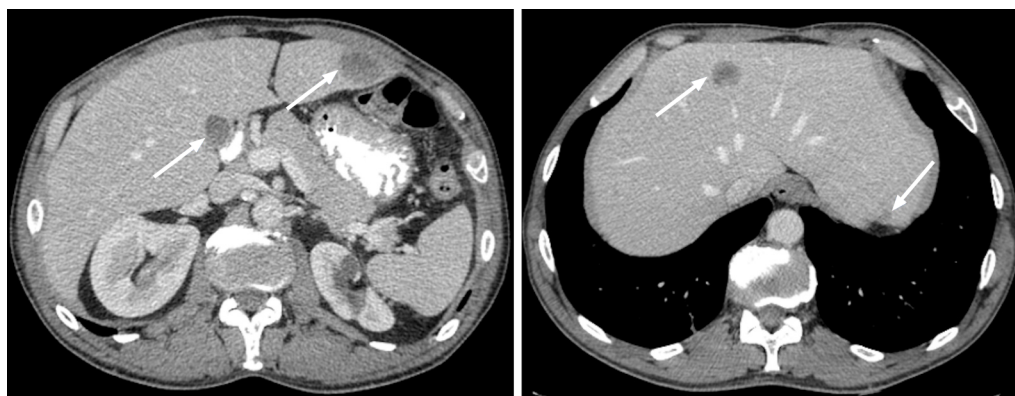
Metastatic lesions from lung cancer. Axial contrast-enhanced computed tomography in the portal-venous phase shows multiple hypodense and hypovascular lesions (arrows) consistent with metastatic lesions from lung cancer.
